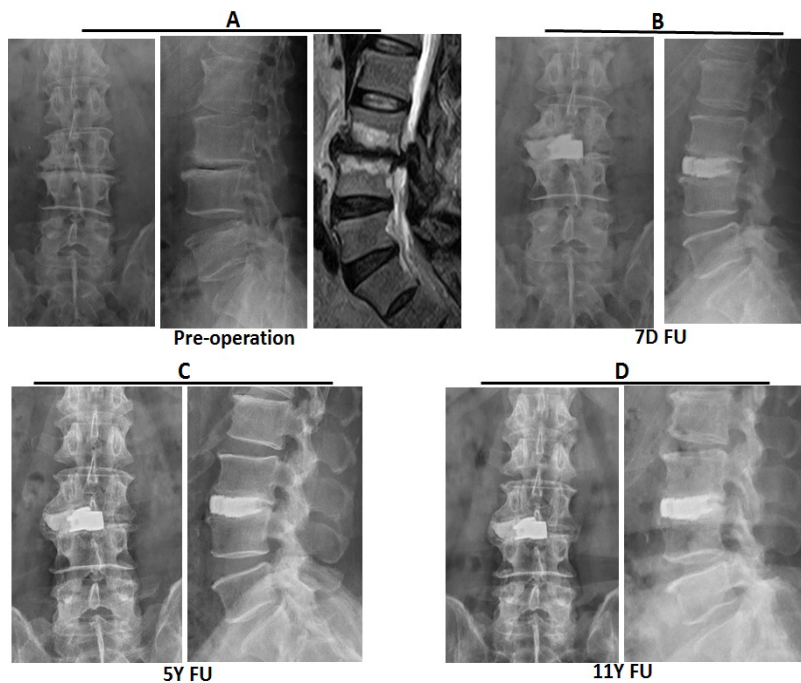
A 63-year-old male with L3/4 retrolisthesis and spinal stenosis (A) received CLIF. The radiographs document the initial post-operative (B), 3-year (C) and 11-year (D) follow-up. The ankylosing bridging spurs were noted.
